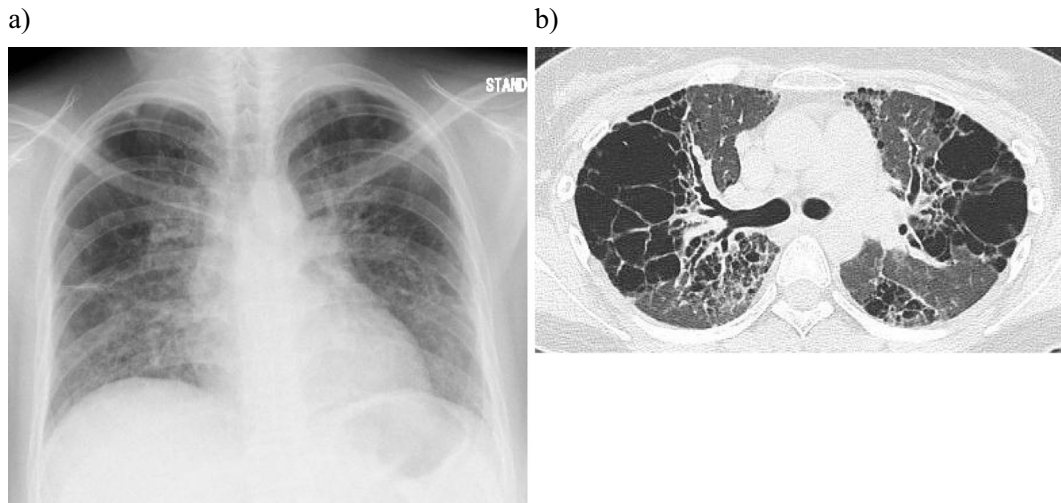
Radiological findings after two months of immunosuppressive therapy. Bilateral ground-glass opacities on chest radiography (a) and computed tomography (b) had improved compared with the imaging findings on admission.
